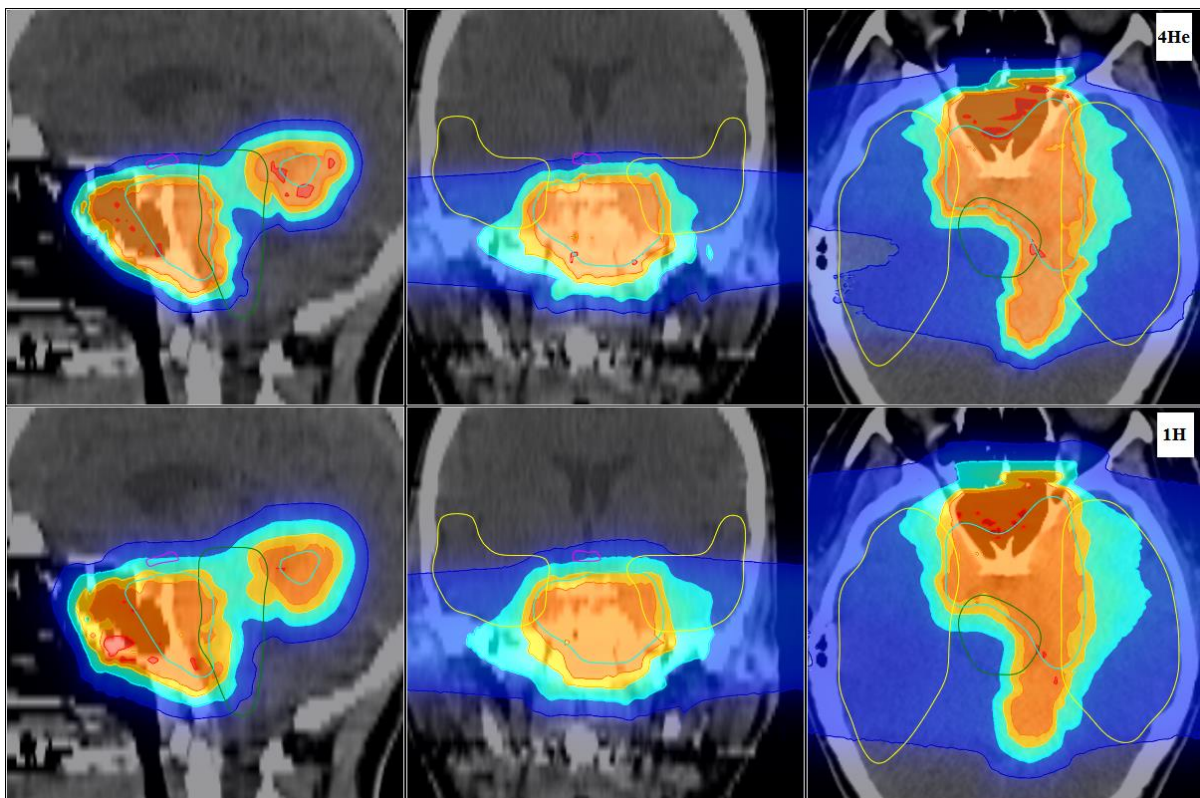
Dose distributions superimposed on the gray scale CT images are shown for patient A, with on the top panels helium ions (4He) and bottom panels protons (1H) for the sagittal, coronal, axial slices.
